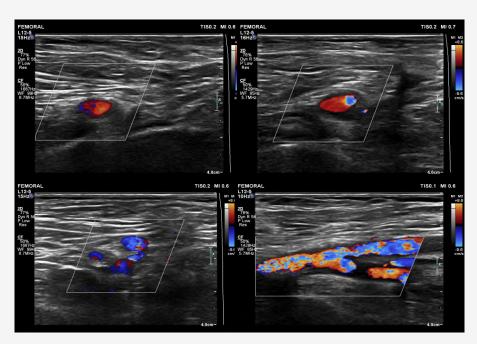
The above ultrasound images were taken to assess the condition of the puncture artery, usually the femoral artery.
